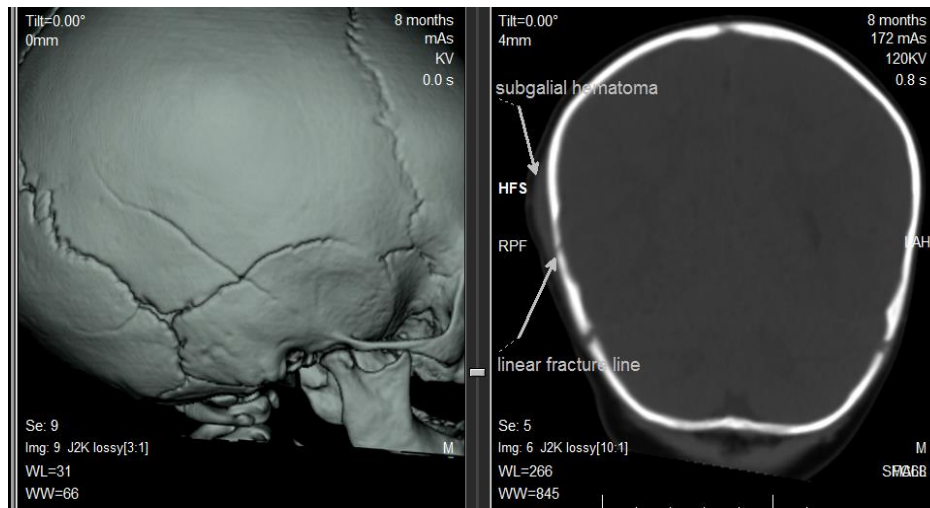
CT scan showing right hair line fracture is seen traversing the right parietal and temporal bone intersecting and traversing the right squamous suture, yet no overriding calvarial bones with small relatively dense right parieto-temporal sub-galial hematoma is seen
